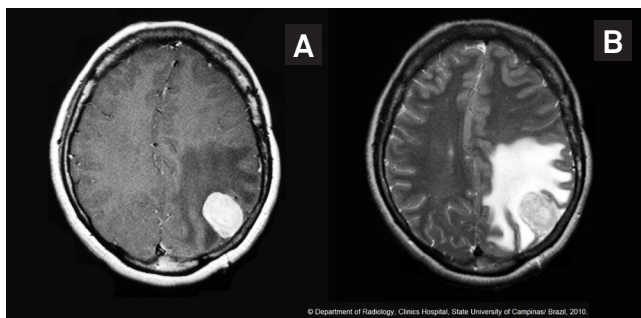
Female, 29 years old. (A) Contrast-enhanced axial T1-weighted magnetic resonance (MR) image shows expansive cortical lesion in the left parietal lobe, with intense enhancement. (B) Axial T2-weighted MR image shows lesion predominantly isointense and moderate edema. Anatomopathology: Mixed tumor, with PXA, ganglioglioma and ependymoma components.
